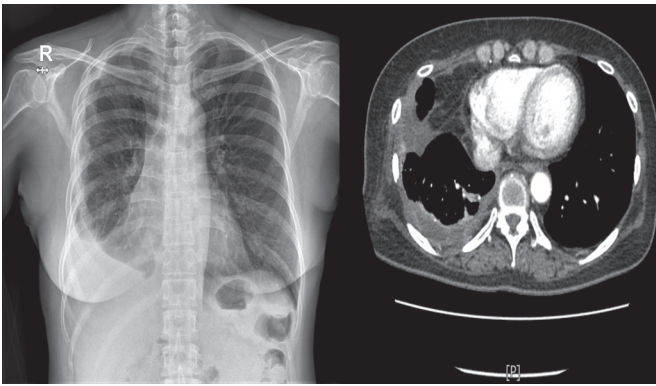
Chest radiograph and chest computed tomography (CT) scan after decortication.
